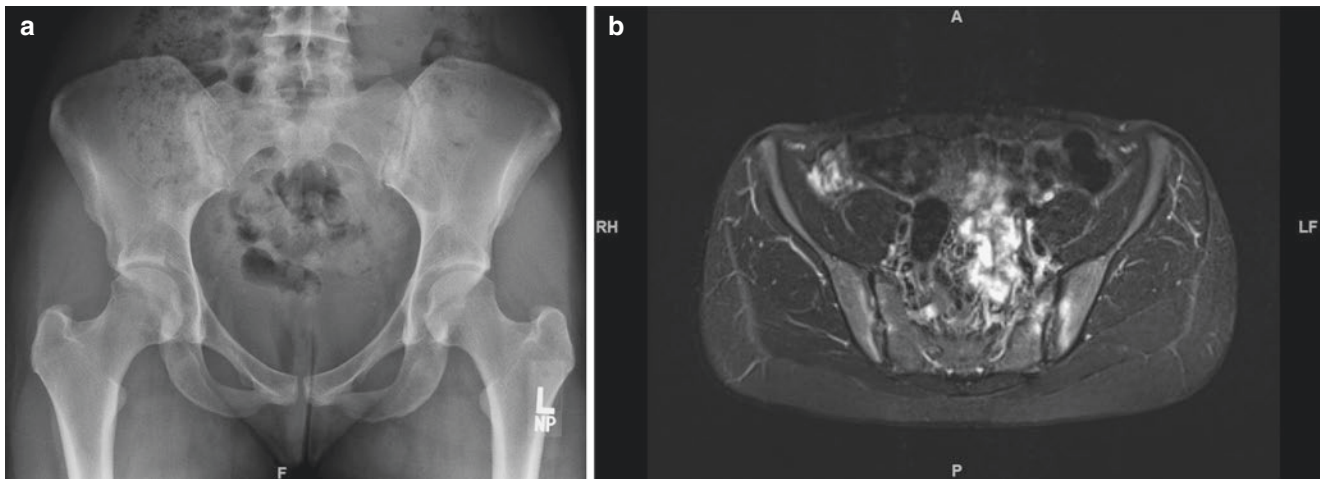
(a) Magnetic resonance imaging (MRI) short tau inversion recovery (STIR) image of the sacroiliac joints and (b) plain anteroposterior radiograph of the pelvis in a 35-year-old woman diagnosed with axial spondyloarthritis/ankylosing spondylitis
